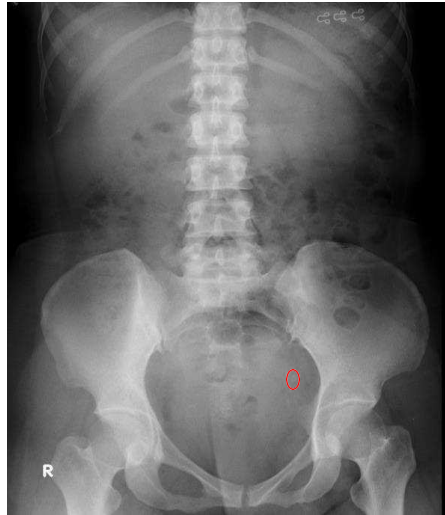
Abdominal X-Ray showing left distal ureterolithiasis
